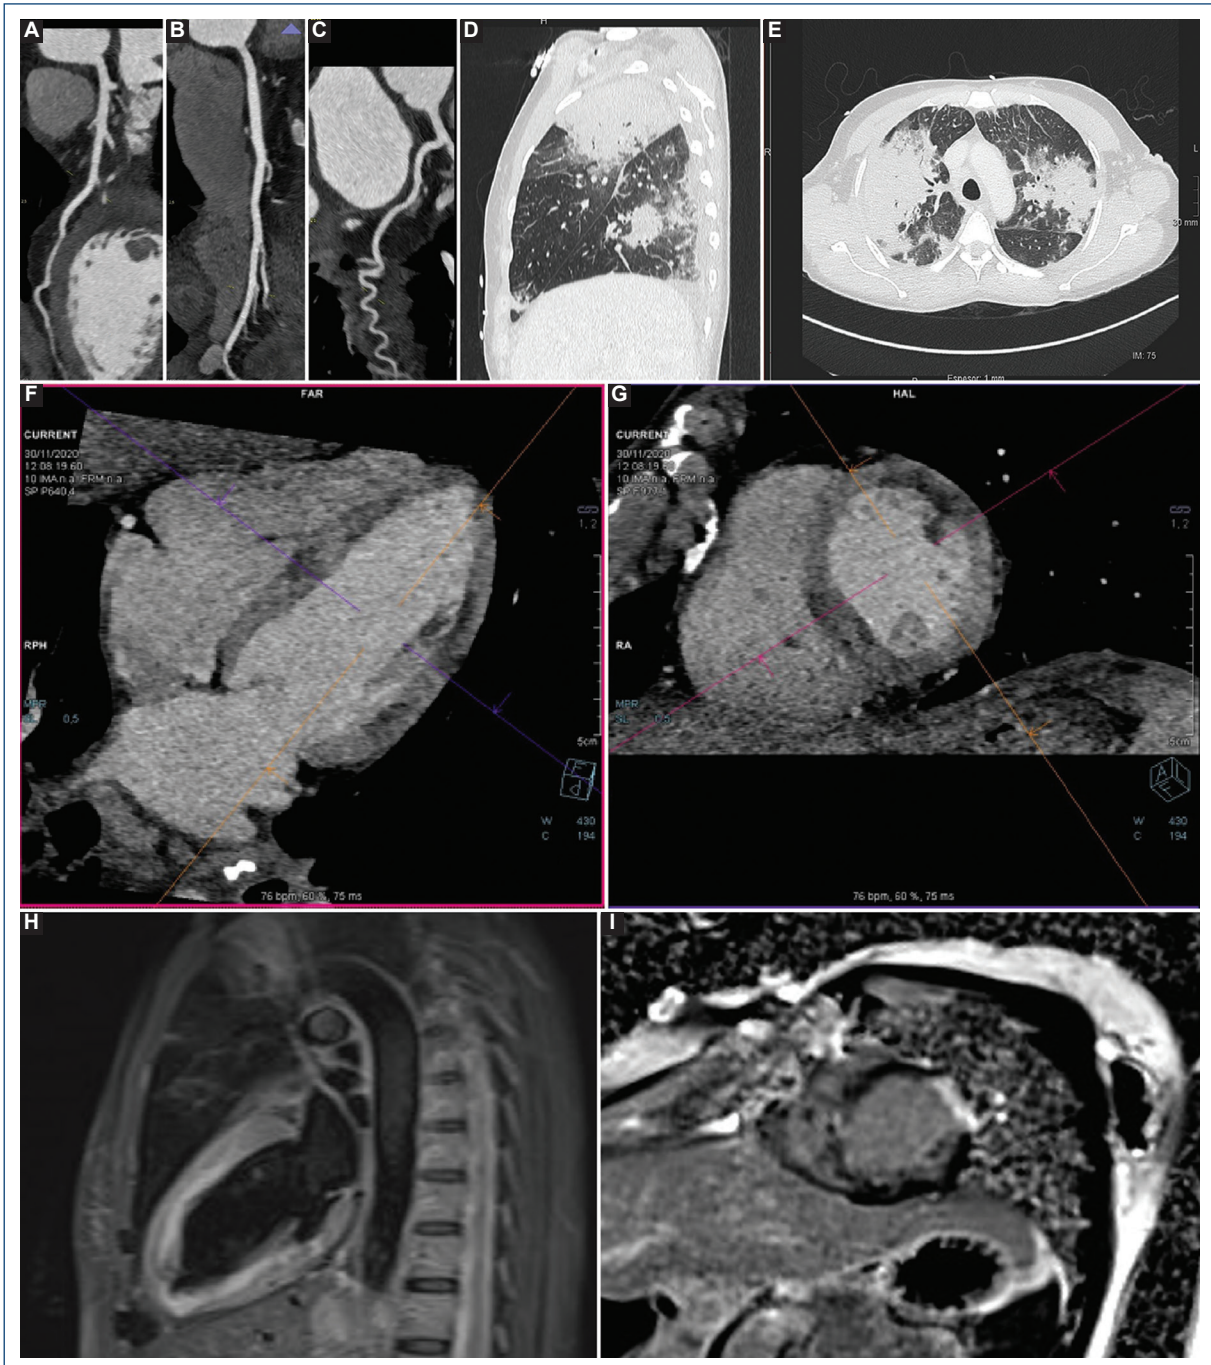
Coronary computed tomography-scan angiography showed no lesions on epicardial coronary arteries. A-C: curved planar reconstruction of left anterior descending, right, and circumflex coronary arteries are shown. D and E: bilateral pulmonary dense opacities and bilateral hilar and mediastinal lymphadenopathies. F and G: four chamber and short axis at papillary muscles views on venous phase in which patchy hypoenhancement areas with no coronary distribution can be appreciated, suggestive of small vessels vasculopathy. Cardiac magnetic resonance showing akinesia and thinning of the middle anterolateral and apical anterior segments. H and I: hypokinesia of the middle septum. Areas of edema and transmural subendocardial late gadolinium enhancement (LGE) in the middle anterolateral segments and a focus of intramyocardial LGE in the middle septal-inferior segment.
